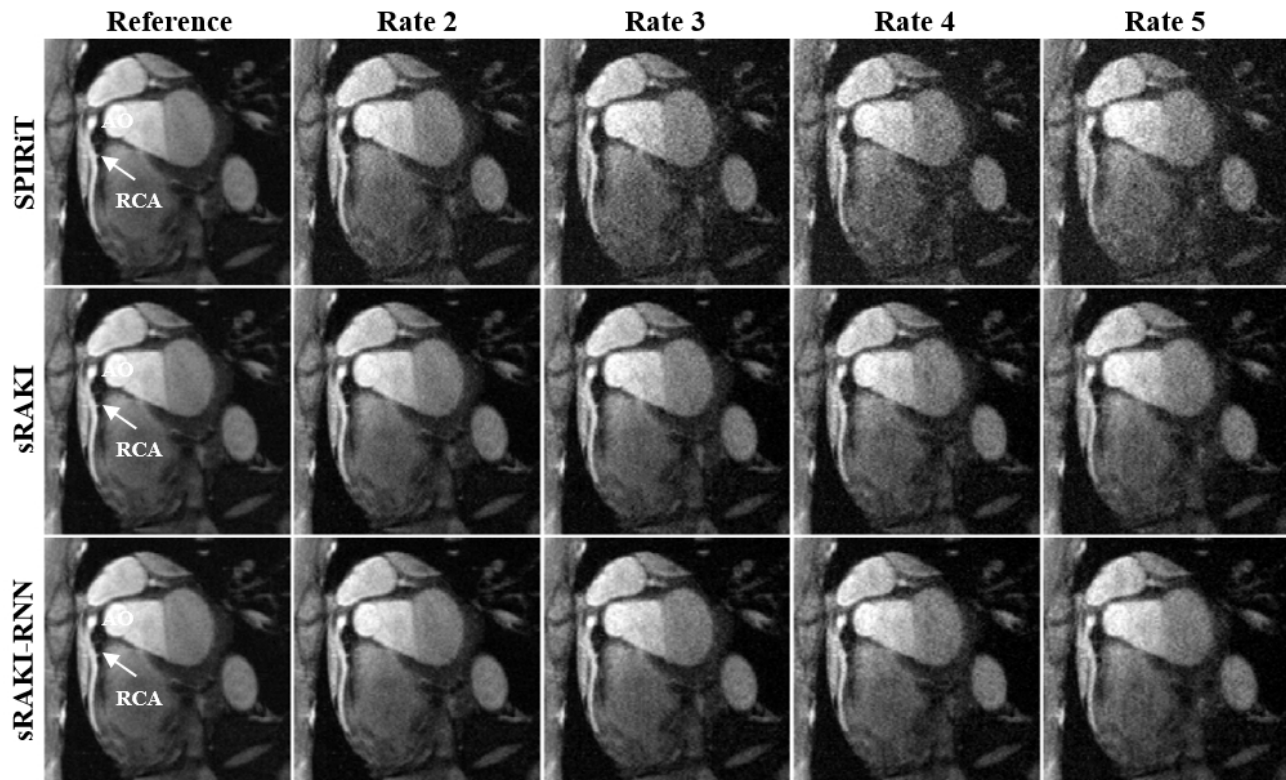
A representative slice from a 3D right coronary artery MRI data of a healthy subject. The data were retrospectively undersampled at rates 2, 3, 4 and 5 in the  $k_y - k_z$  plane and then reconstructed using techniques SPIRiT, sRAKI and sRAKI-RNN (top, middle and bottom rows). The fully-sampled images are provided in the first column as a reference for comparison. All techniques successfully remove aliasing artifacts, and the least reconstruction noise is achieved by sRAKI-RNN. (RCA: right coronary artery; AO: aortic root)
